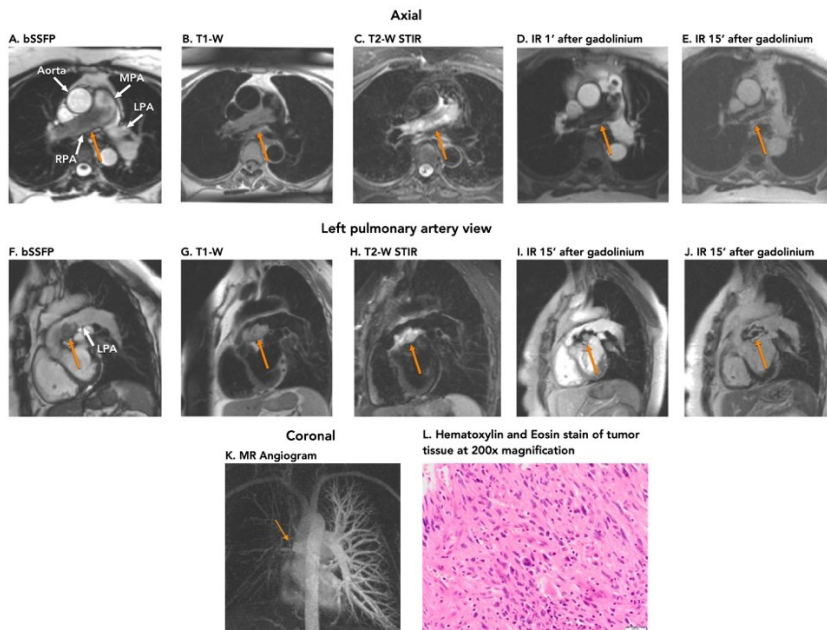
Malignant peripheral nerve sheath tumor (MPNST). A 41 year old man presented with chest pain and breathlessness. A lobulated heterogeneous mass between the aortic root, pulmonary arteries and left atrium (orange arrows) was seen on CMR (axial plane in top panel, vertical long axis plane in bottom panel). It was mildly heterogeneous on T1-weighted and bSSFP images (A, C) and hyperintense as well as heterogeneous on T2-weighted images (B). The enhancement pattern on late phase inversion recovery image (D) indicates a fluid-filled necrotic component. The location suggests it may have originated from the pulmonary plexus. Previously known as malignant schwannoma, neurogenic sarcoma, and neurofibrosarcoma, malignant peripheral nerve sheath tumor is a neoplasm of peripheral neural origin and is often associated with neurofibromatosis type I.
